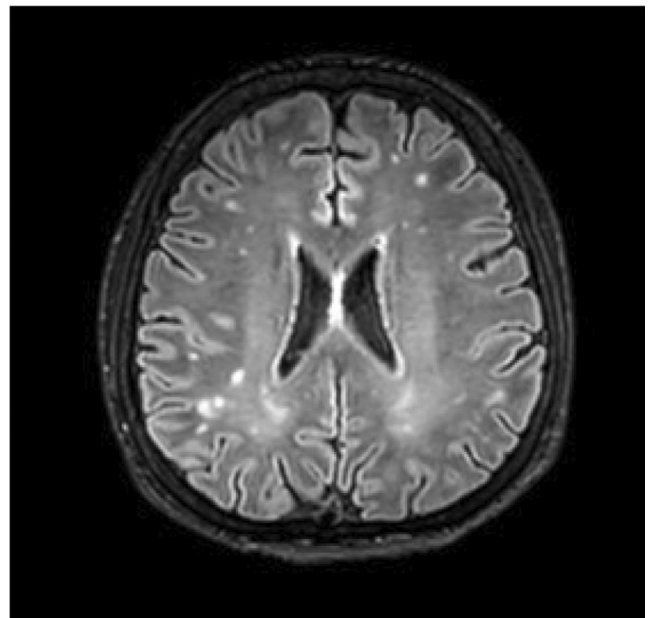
Patient 1. Parenchymal lesions in both cerebral hemispheres, asymmetric, FLAIR hyperintense with an inflammatory appearance.
